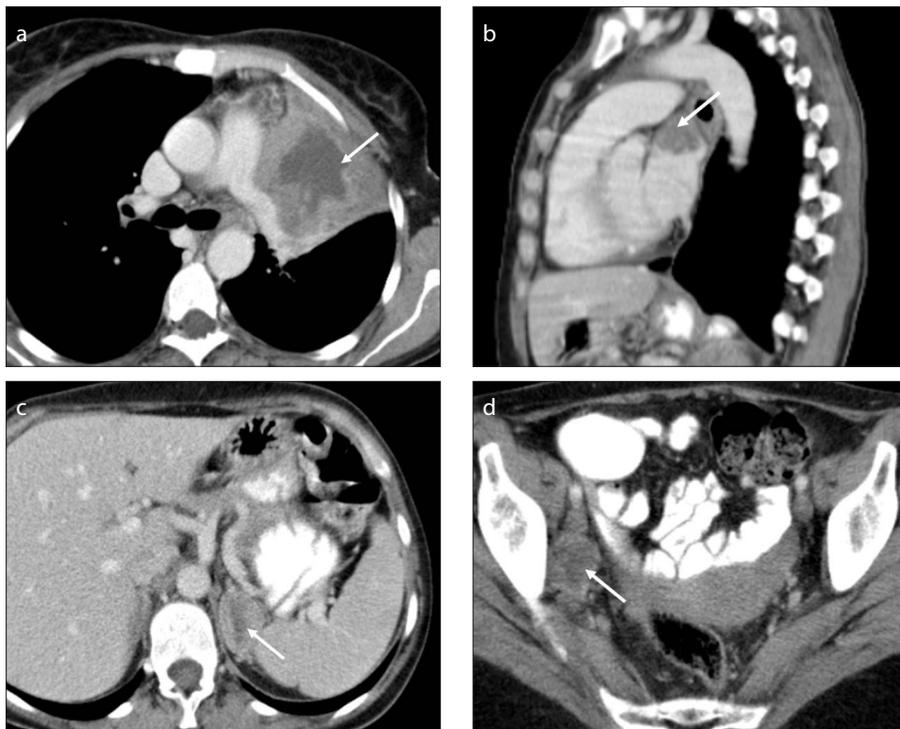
a–d. Distant and lymph node recurrence. CT images (sagittal of the thorax and axial planes at different levels) of a patient with cardiac, lung and left adrenal metastases and obturator lymph node involvement (*white arrows*) of squamous cell carcinoma of the cervix, 15 months after treatment. There is a mass in the left lung apex that invades the heart (left atria) and a heterogeneous lesion on the left adrenal gland *de novo*. In the pelvis, only an obturator lymph node metastasis was noted.
